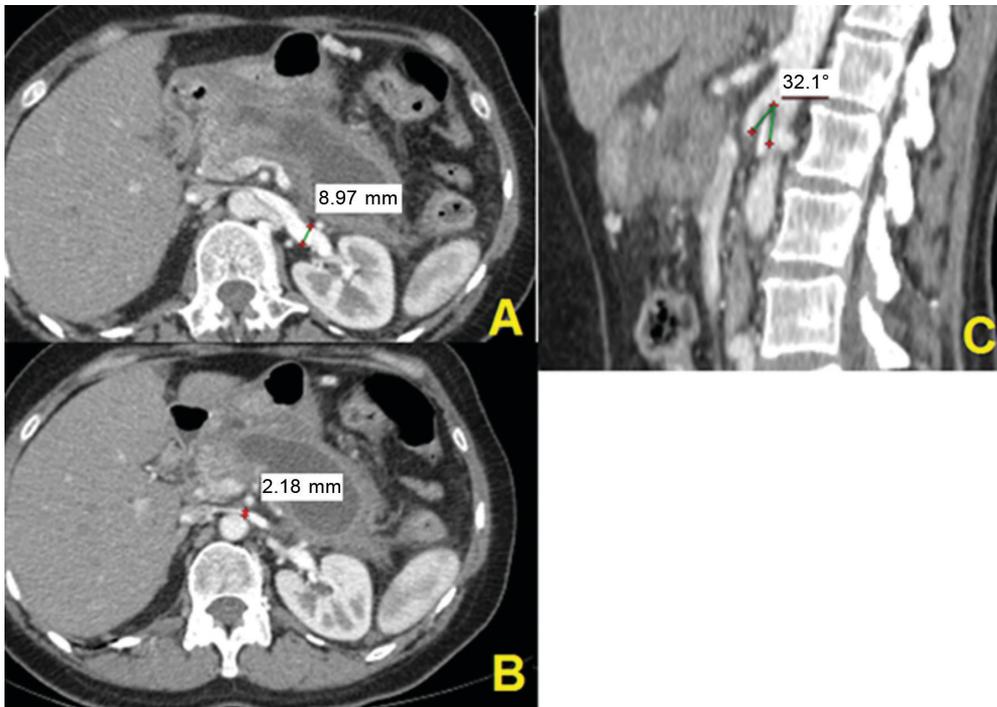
Computed tomography with intravenous contrast (patient n 67). (A) Diameter of the left renal vein at the renal hilum; (B) Diameter of the left renal vein at the level of the aortomesenteric angle; (C) Measurement of the aortomesenteric angle on a sagittal slice.
